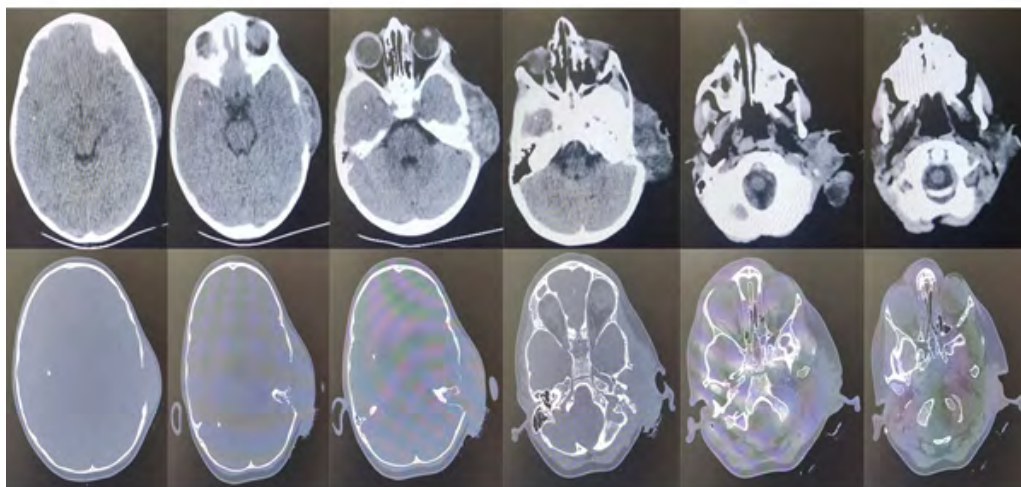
Axial brain computed tomography (CT) images at the time of diagnosis.
